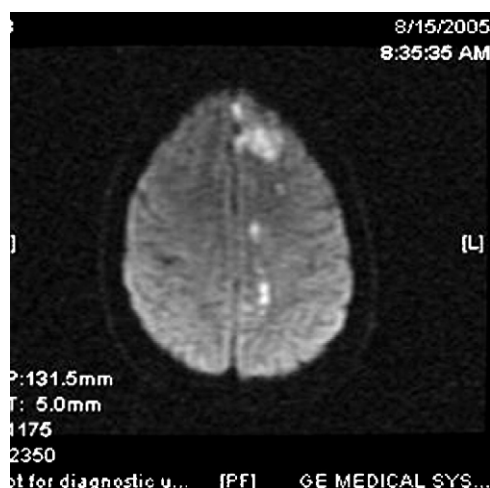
Acute infarction in the left MCA and ACA watershed territory on diffusion-weighted MRI of the brain.
